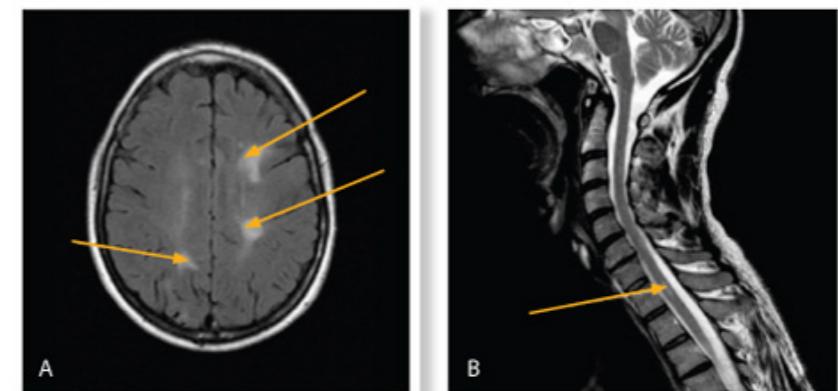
MRI scans showing inflammatory lesions of MS in a newly diagnosed person with numbness in one leg.
